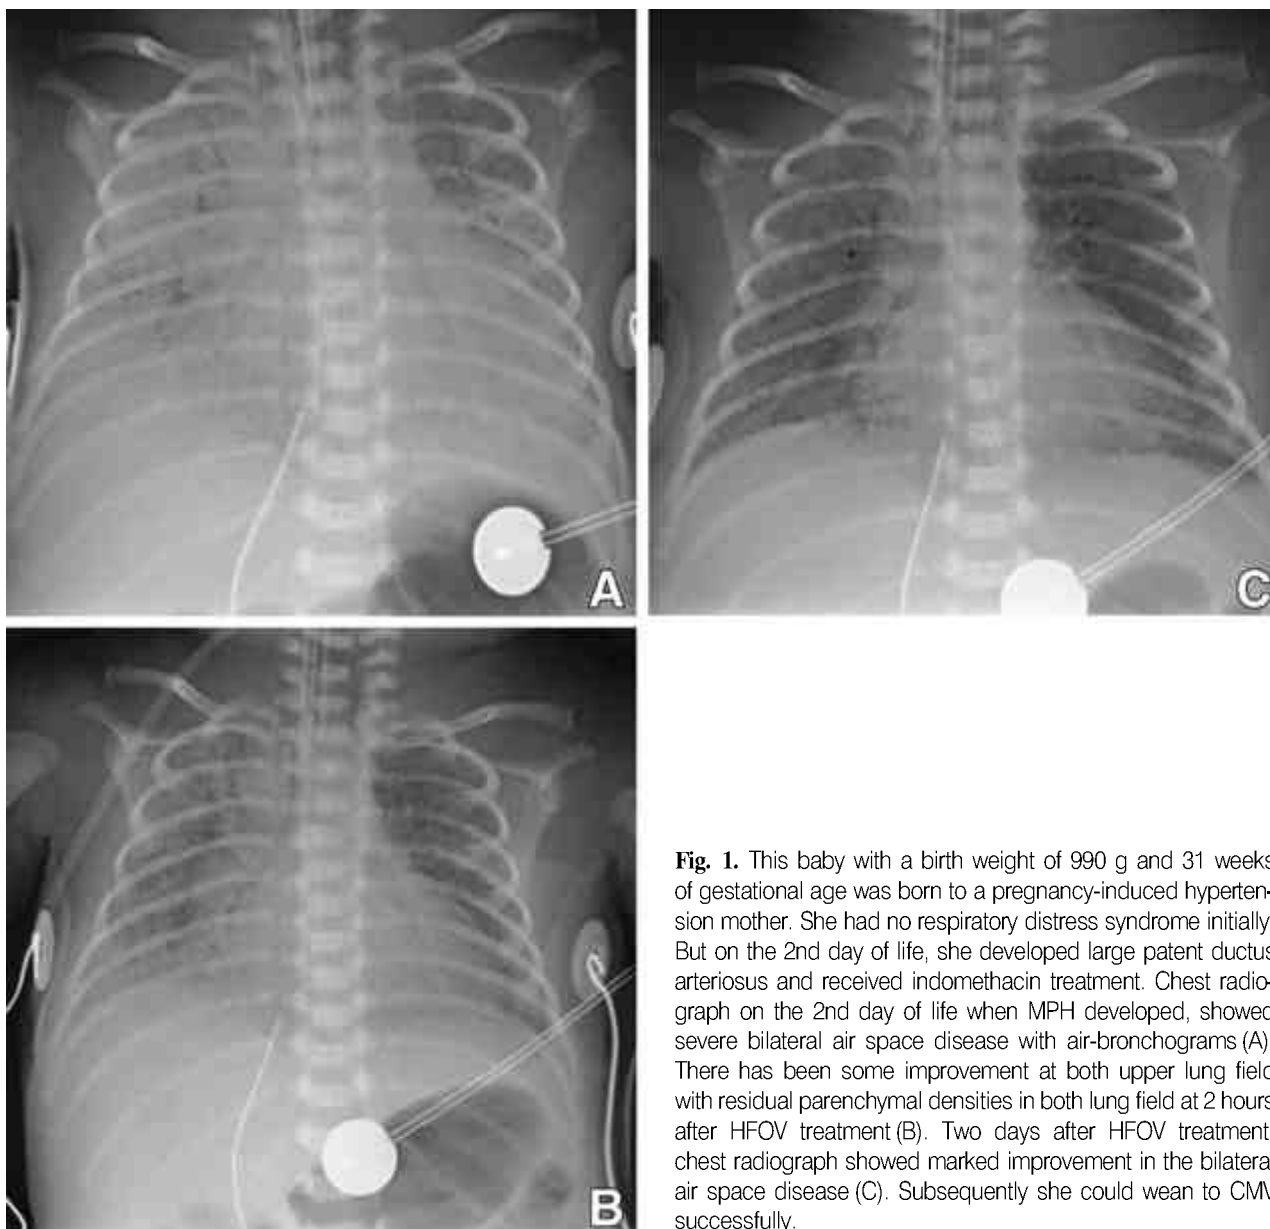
This baby with a birth weight of 990 g and 31 weeks of gestational age was born to a pregnancy-induced hypertension mother. She had no respiratory distress syndrome initially. But on the 2nd day of life, she developed large patent ductus arteriosus and received indomethacin treatment. Chest radiograph on the 2nd day of life when MPH developed, showed severe bilateral air space disease with air-bronchograms (A). There has been some improvement at both upper lung field with residual parenchymal densities in both lung field at 2 hours after HFOV treatment (B). Two days after HFOV treatment, chest radiograph showed marked improvement in the bilateral air space disease (C). Subsequently she could wean to CMV successfully.
